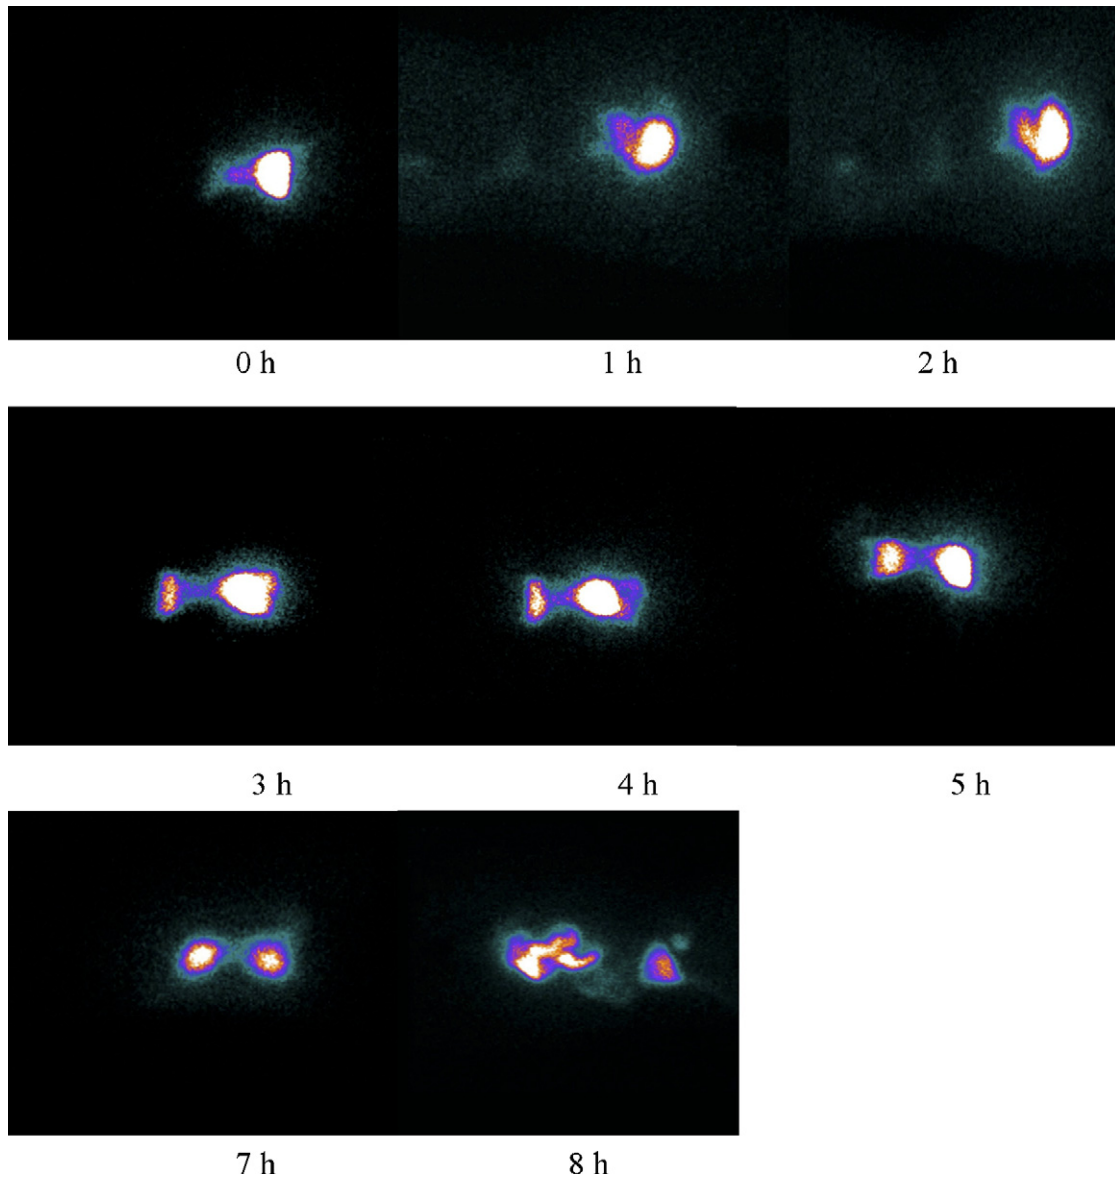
Gamma scintigraphic images of ion-exchange fiber in fasted volunteer.
